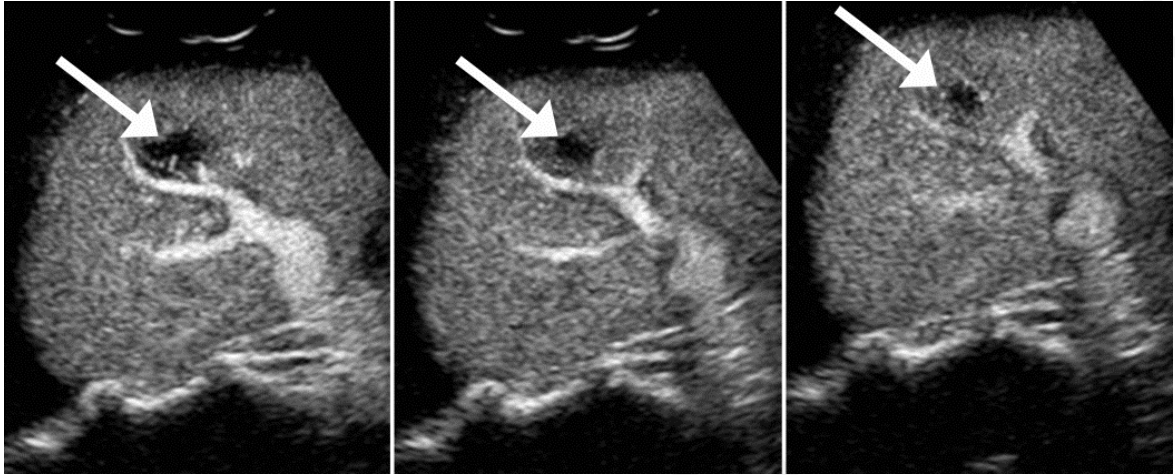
Example of the changes of the size, location, and shape of a liver lesion, in a dynamic contrast-enhanced ultrasound (DCEUS) loop, at three different time instances. These changes are mainly attributed to respiratory motion.
